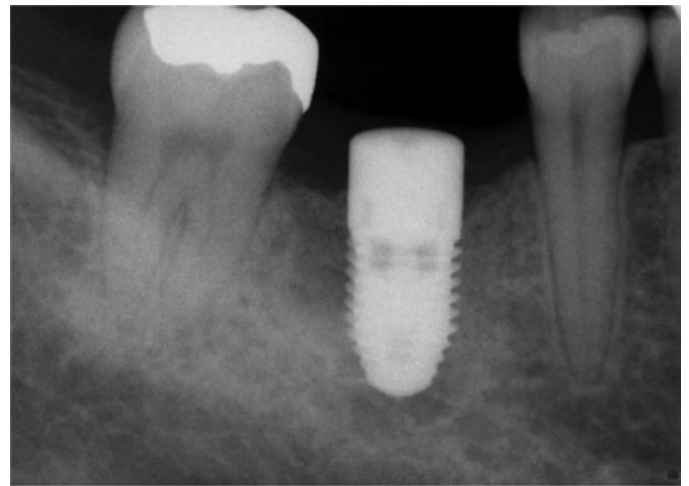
(E) Replacement of the implant 4 months following the implant removal and ridge augmentation. Radiographic view of the implant after a 3-month integration period. Note the improved position and larger diameter that could be placed due to the corrected position relative to the adjacent roots.
